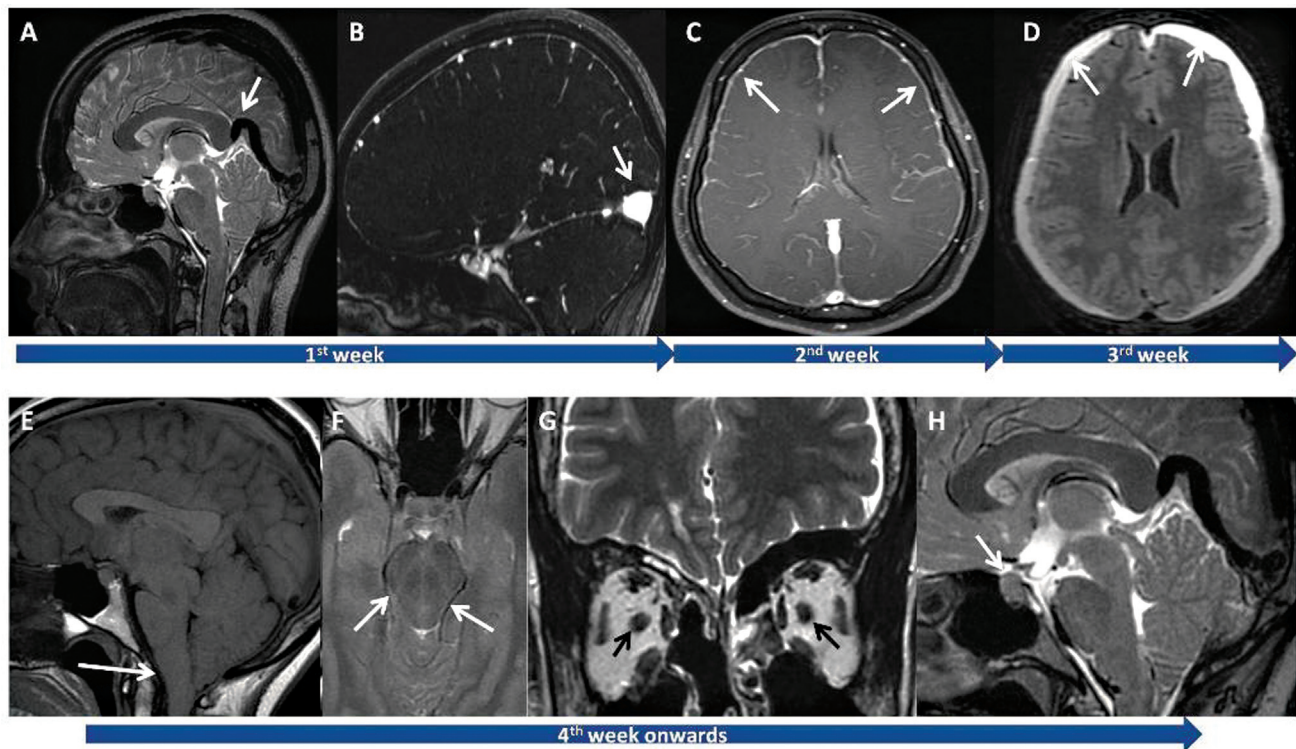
Sequence of magnetic resonance imaging findings in spontaneous intracranial hypotension. (A) Sagittal T2 image through the brain showing enlarged tortuous straight sinus (white arrow). (B) Sagittal T1 post-contrast image showing rounded venous sinuses with convex inferior borders (white arrow). (C) Axial T1-weighted post-contrast image showing non-nodular, diffuse supratentorial pachymeningeal thickening with enhancement (white arrows). (D) Axial fluid-attenuated inversion recovery image showing bilateral cerebral convexity subdural collections (white arrows). (E) Sagittal T1 image of the brain showing sagging of the parenchyma into the foramen magnum (white arrow). (F) Axial T2 image showing increased anteroposterior diameter of the midbrain with squeezing (white arrow). (G) Coronal T2-weighted image showing reduced cerebrospinal fluid around the bilateral optic nerves (black arrows). (H) Sagittal T2 image showing pituitary engorgement seen as an enlarged dome like pituitary (white arrow).
